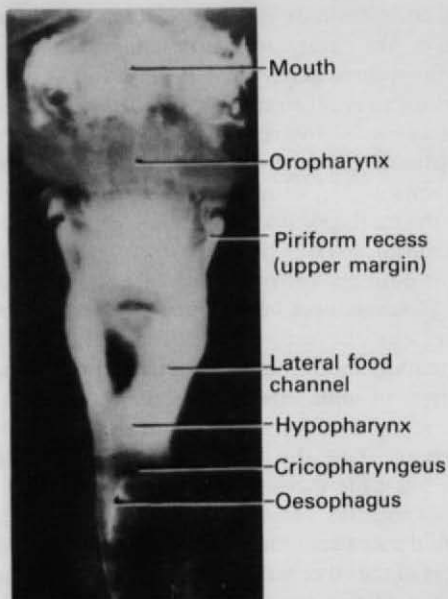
Radiograph during swallowing, showing division of the bolus into the lateral channel (piriform recess) on each side of the larynx.
